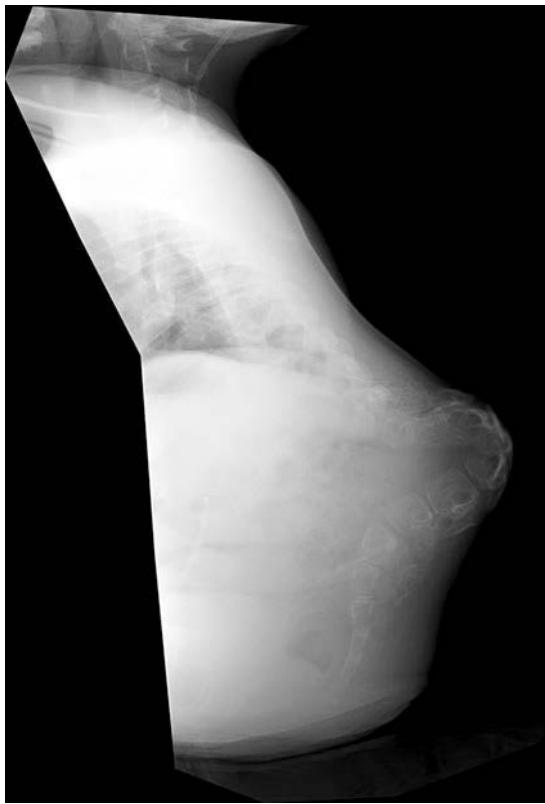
Preoperative x-ray demonstrating the severe kyphosis.
